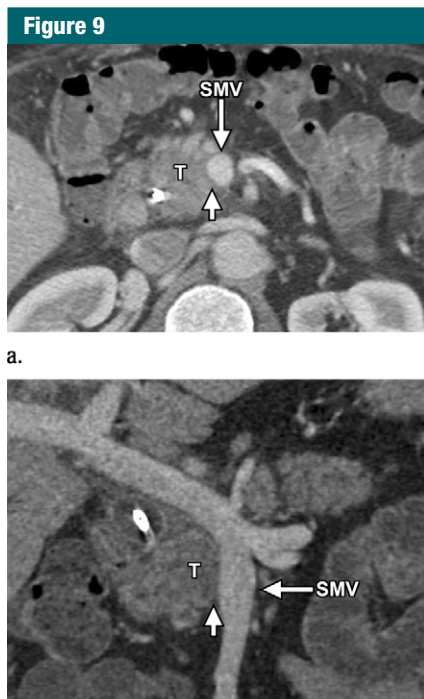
Images in a 55-year-old woman with tumor with less than 180° of contact with the SMV. (a) Axial contrast-enhanced biphasic multidetector CT angiogram demonstrates a pancreatic head mass (*T*) contacting less than 180° of the SMV circumference without contour deformity or focal narrowing (short arrow). (b) The length of contact and vessel caliber is better delineated on the coronal reformatted image (short arrow). The limited tumor contact with the SMV and the identification of suitable vessel proximal and distal to the lesion, which allows safe resection and venous replacement, places the patient in the borderline resectable category.
